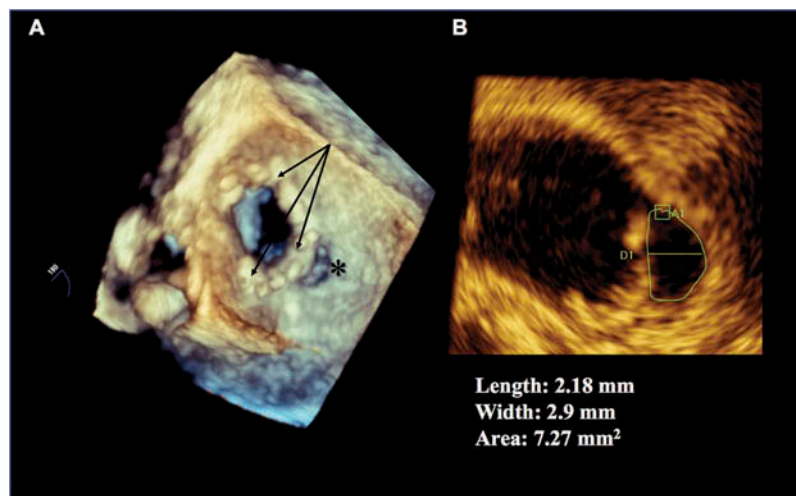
3D and 2D-transesophageal echocardiographic assessment of a posterior mitral paravalvular leak. 3-dimensional echocardiography allows for a comprehensive understanding of the defect (*) and the location of surrounding structures (e.g., prosthetic annulus – arrows) (A). Measurement of the defect is done with 2D TEE imaging (B).
